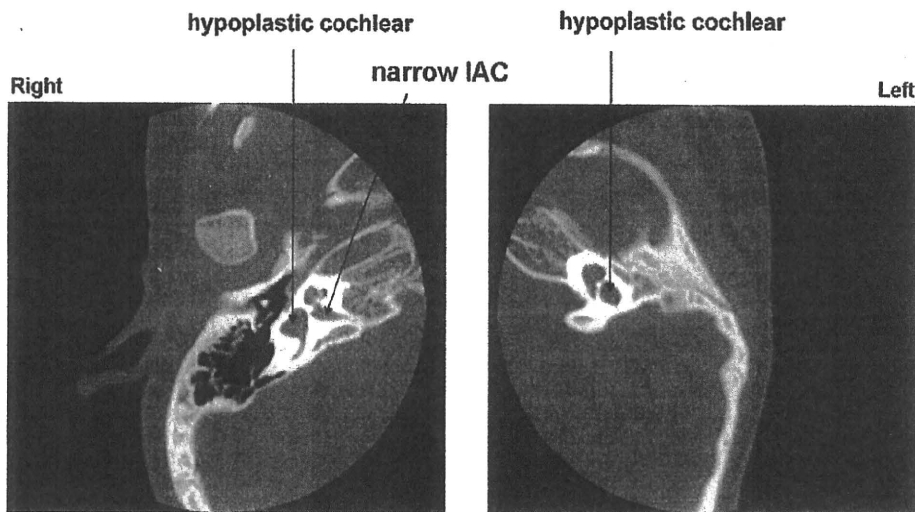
CT scan showing narrow IAC with hypoplastic cochlear in case 2.
